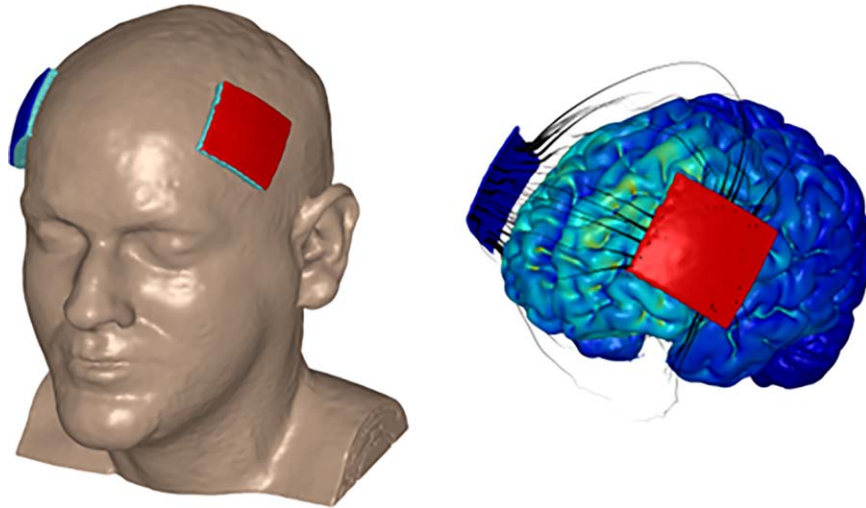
Working memory CT is associated with increased perfusion of left precentral gyrus/frontal middle gyrus/superior frontal gyrus. The “OLE” DLPFC tDCS montage is optimized to target similar regions (62). [Color figure can be viewed at wileyonlinelibrary.com]
